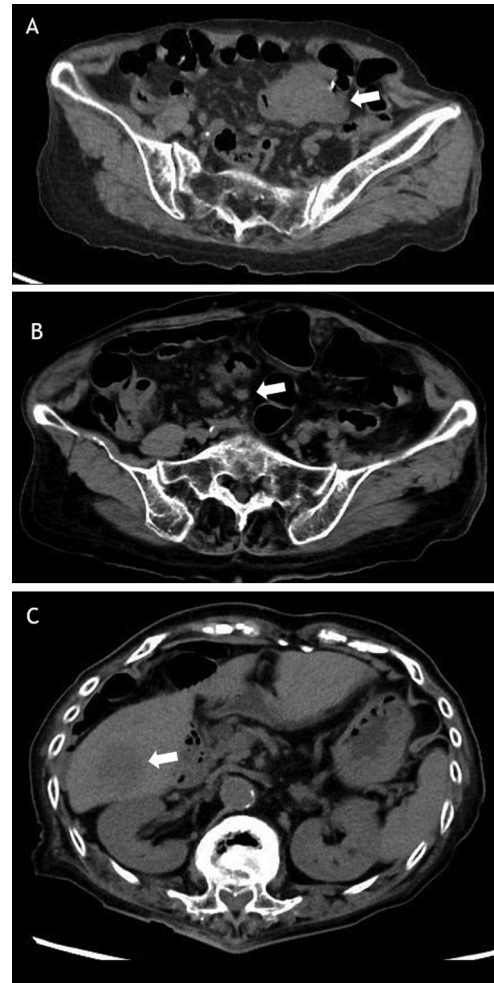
Abdominal computed tomography scan showing A) a tumor in the cecum, B) one liver metastasis, and C) one swollen lymph node at the back of the cecal tumor.
